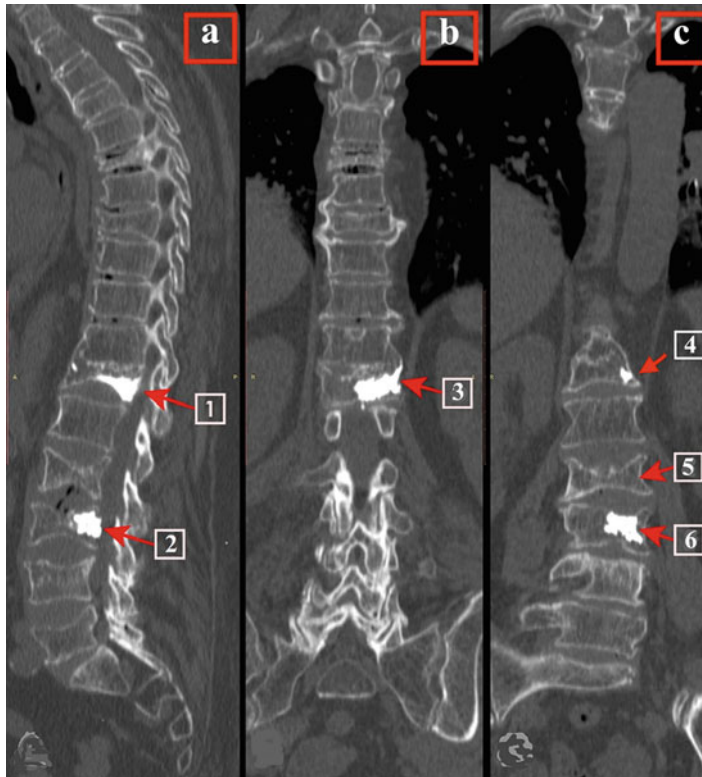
CT scans of a 72-year-old woman, taken 2 years after she had been treated with percutaneous vertebroplasty due to compression fracture: (a) sagittal plane – arrows 1 and 2 show cement injected into Th₁₂ and L₃ vertebrae; (b) coronal plane – arrow 3 shows extra-vertebral leakage of the cement from Th₁₂ to the adjacent
